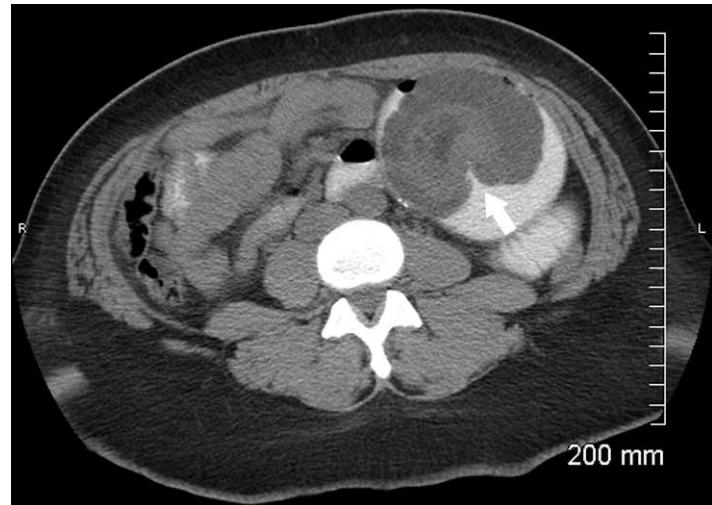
Computed tomography with oral and intravenous contrast showing the pathognomonic “target sign” (white arrow).
